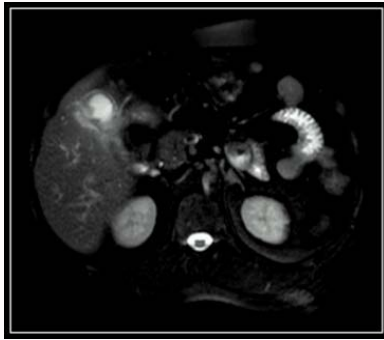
Axial T2W MR images reveal diffuse asymmetric circumferential mural thickening of gallbladder with adjacent hepatic parenchymal infiltration.
